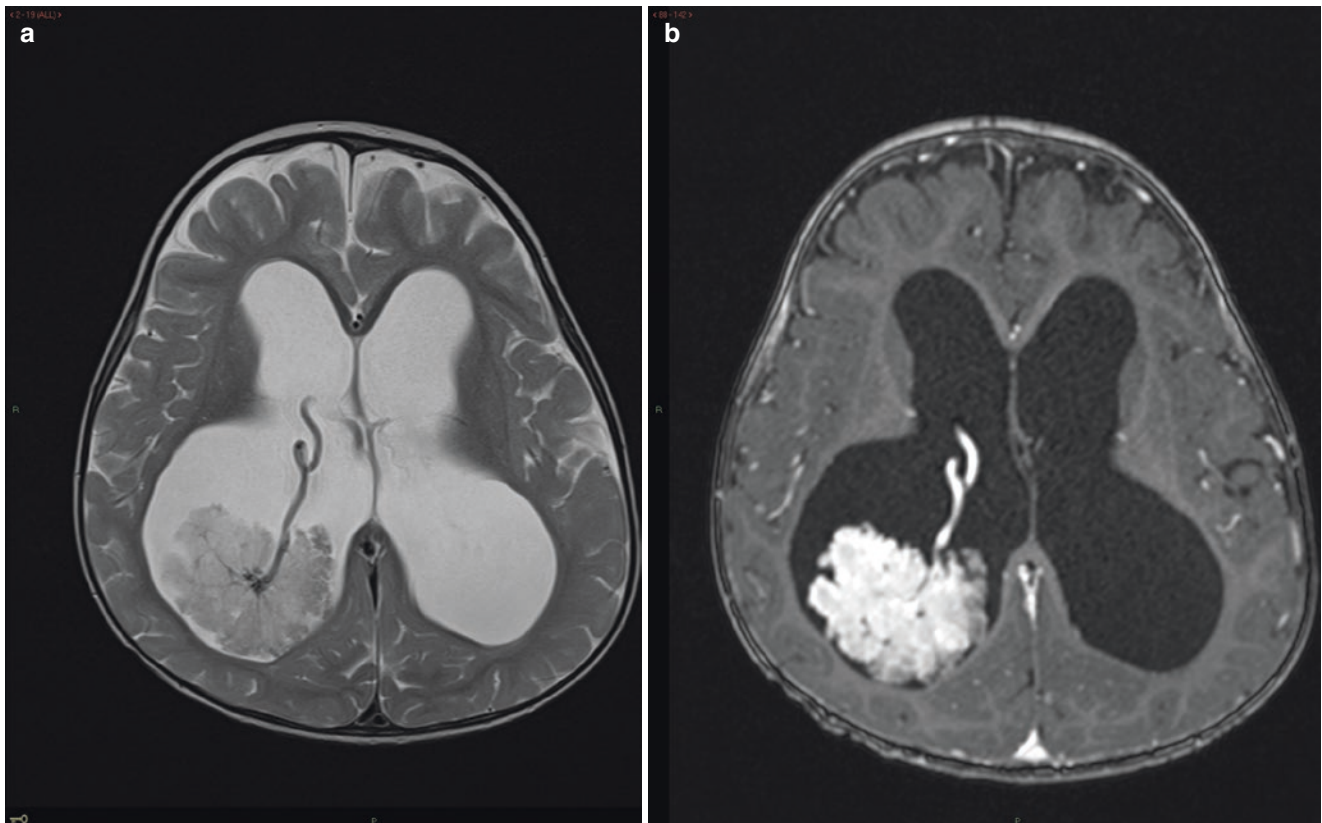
Choroid plexus papilloma. (a) Axial T2-weighted MR image shows a lobulated mass within the right lateral ventricle. A large feeding vessel is visible. (b) Axial post-contrast T1-weighted image
